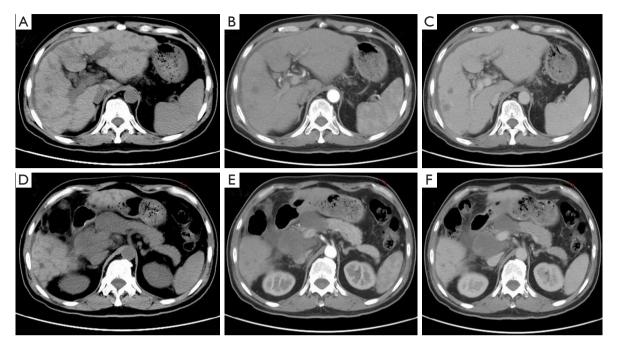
CT images after six courses of HAIC: the size of the largest liver mass and partial portal lymph nodes was markedly decreased. Postcontrast CT image of the (A,D) arterial phase, (B,E) portal venous phase, and (C,F) delayed phase. CT, computed tomography; HAIC, hepatic arterial infusion chemotherapy.
